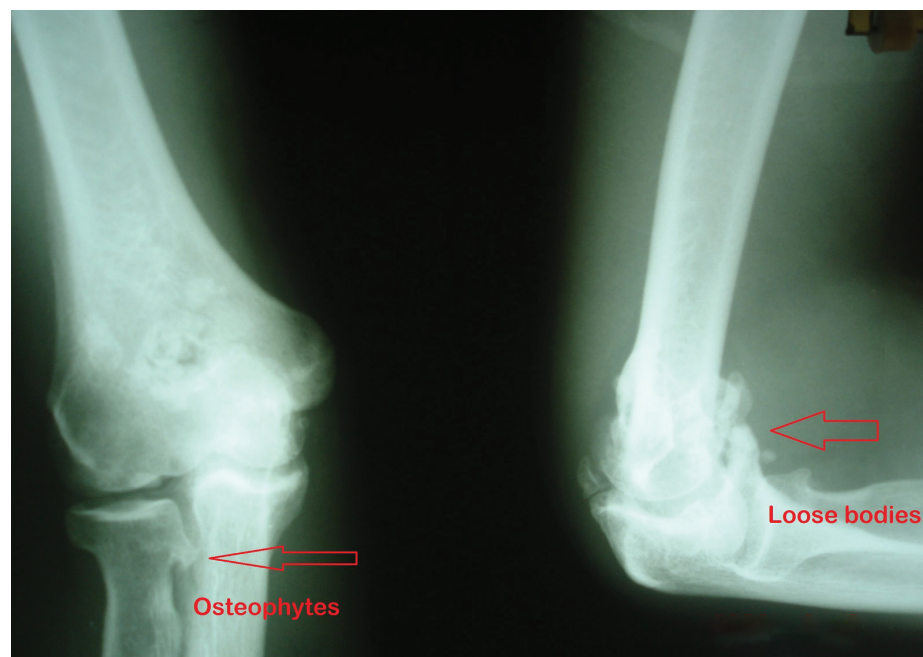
X-ray image of the right elbow. Anteroposterior and a lateral view showing multiple loose bodies, narrowing of the joint space, subchondral sclerosis, and osteophyte formation.
